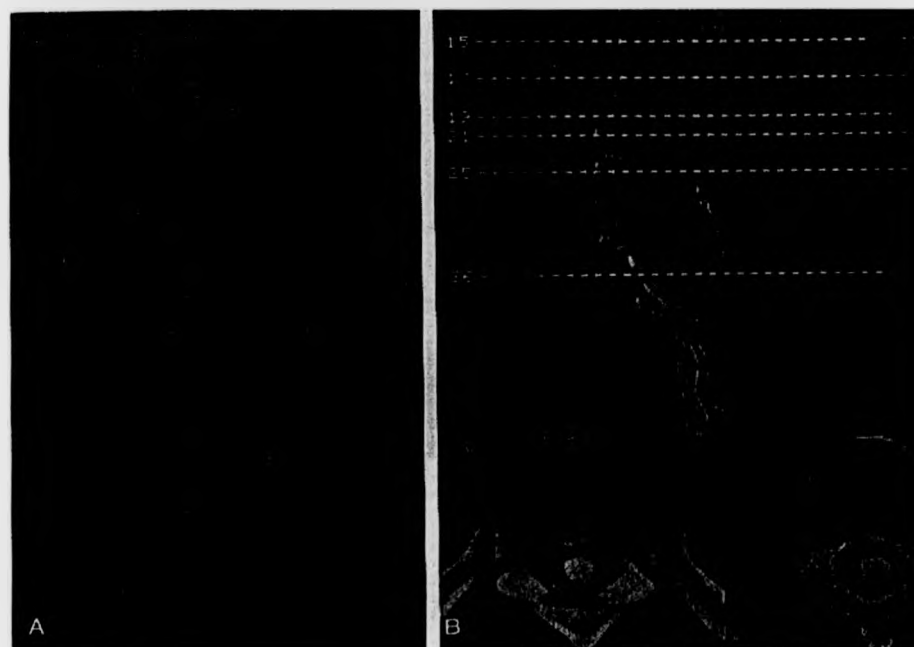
(A) A myelography in post-traumatic syringomyelia. (B) Computed tomography scan about 1 hour after myelography. (Williams, 1990b, p. 673)
